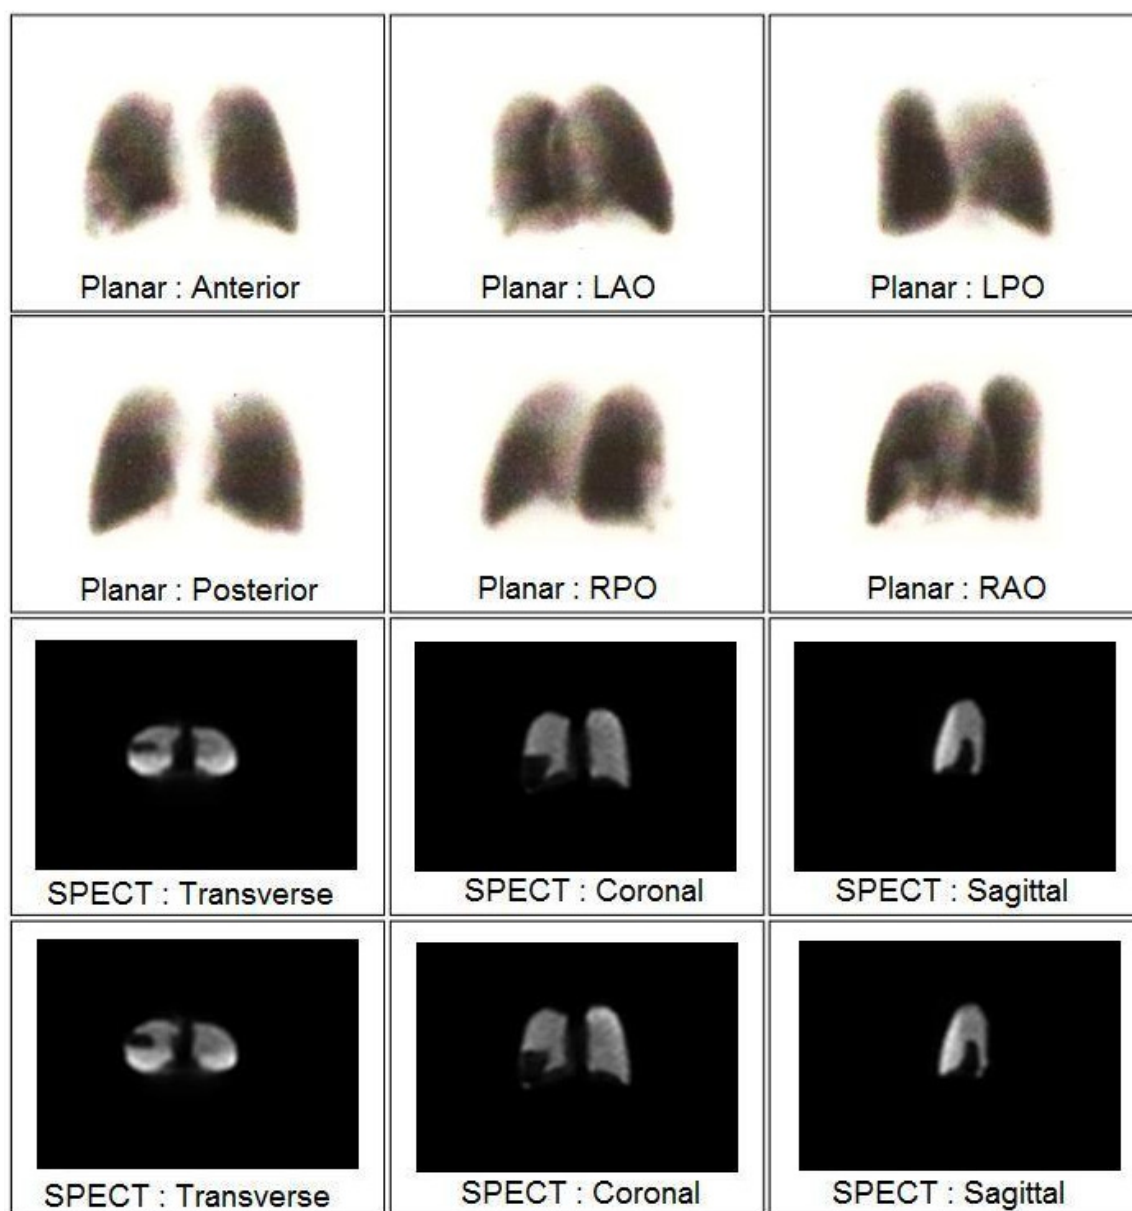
Planar and SPECT images of a perfusion defect within the anterior basal segment of the right lower lobe.
